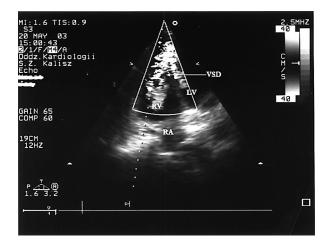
Echocardiographic examination. Apical four-chamber modified view. In examination with colour-coded Doppler an evident flow appears from the left ventricle (LV) to the right ventricle (RV) through the ventricular septal defect (VSD), right atrium (RA).
